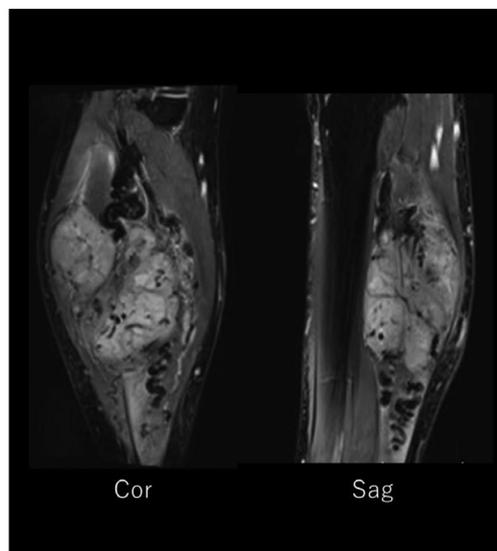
Magnetic resonance imaging pre-CIRT of pelvis and leg. The pelvic tumor diameter was 11.9 cm and that of the leg tumor was 11.0 cm.
